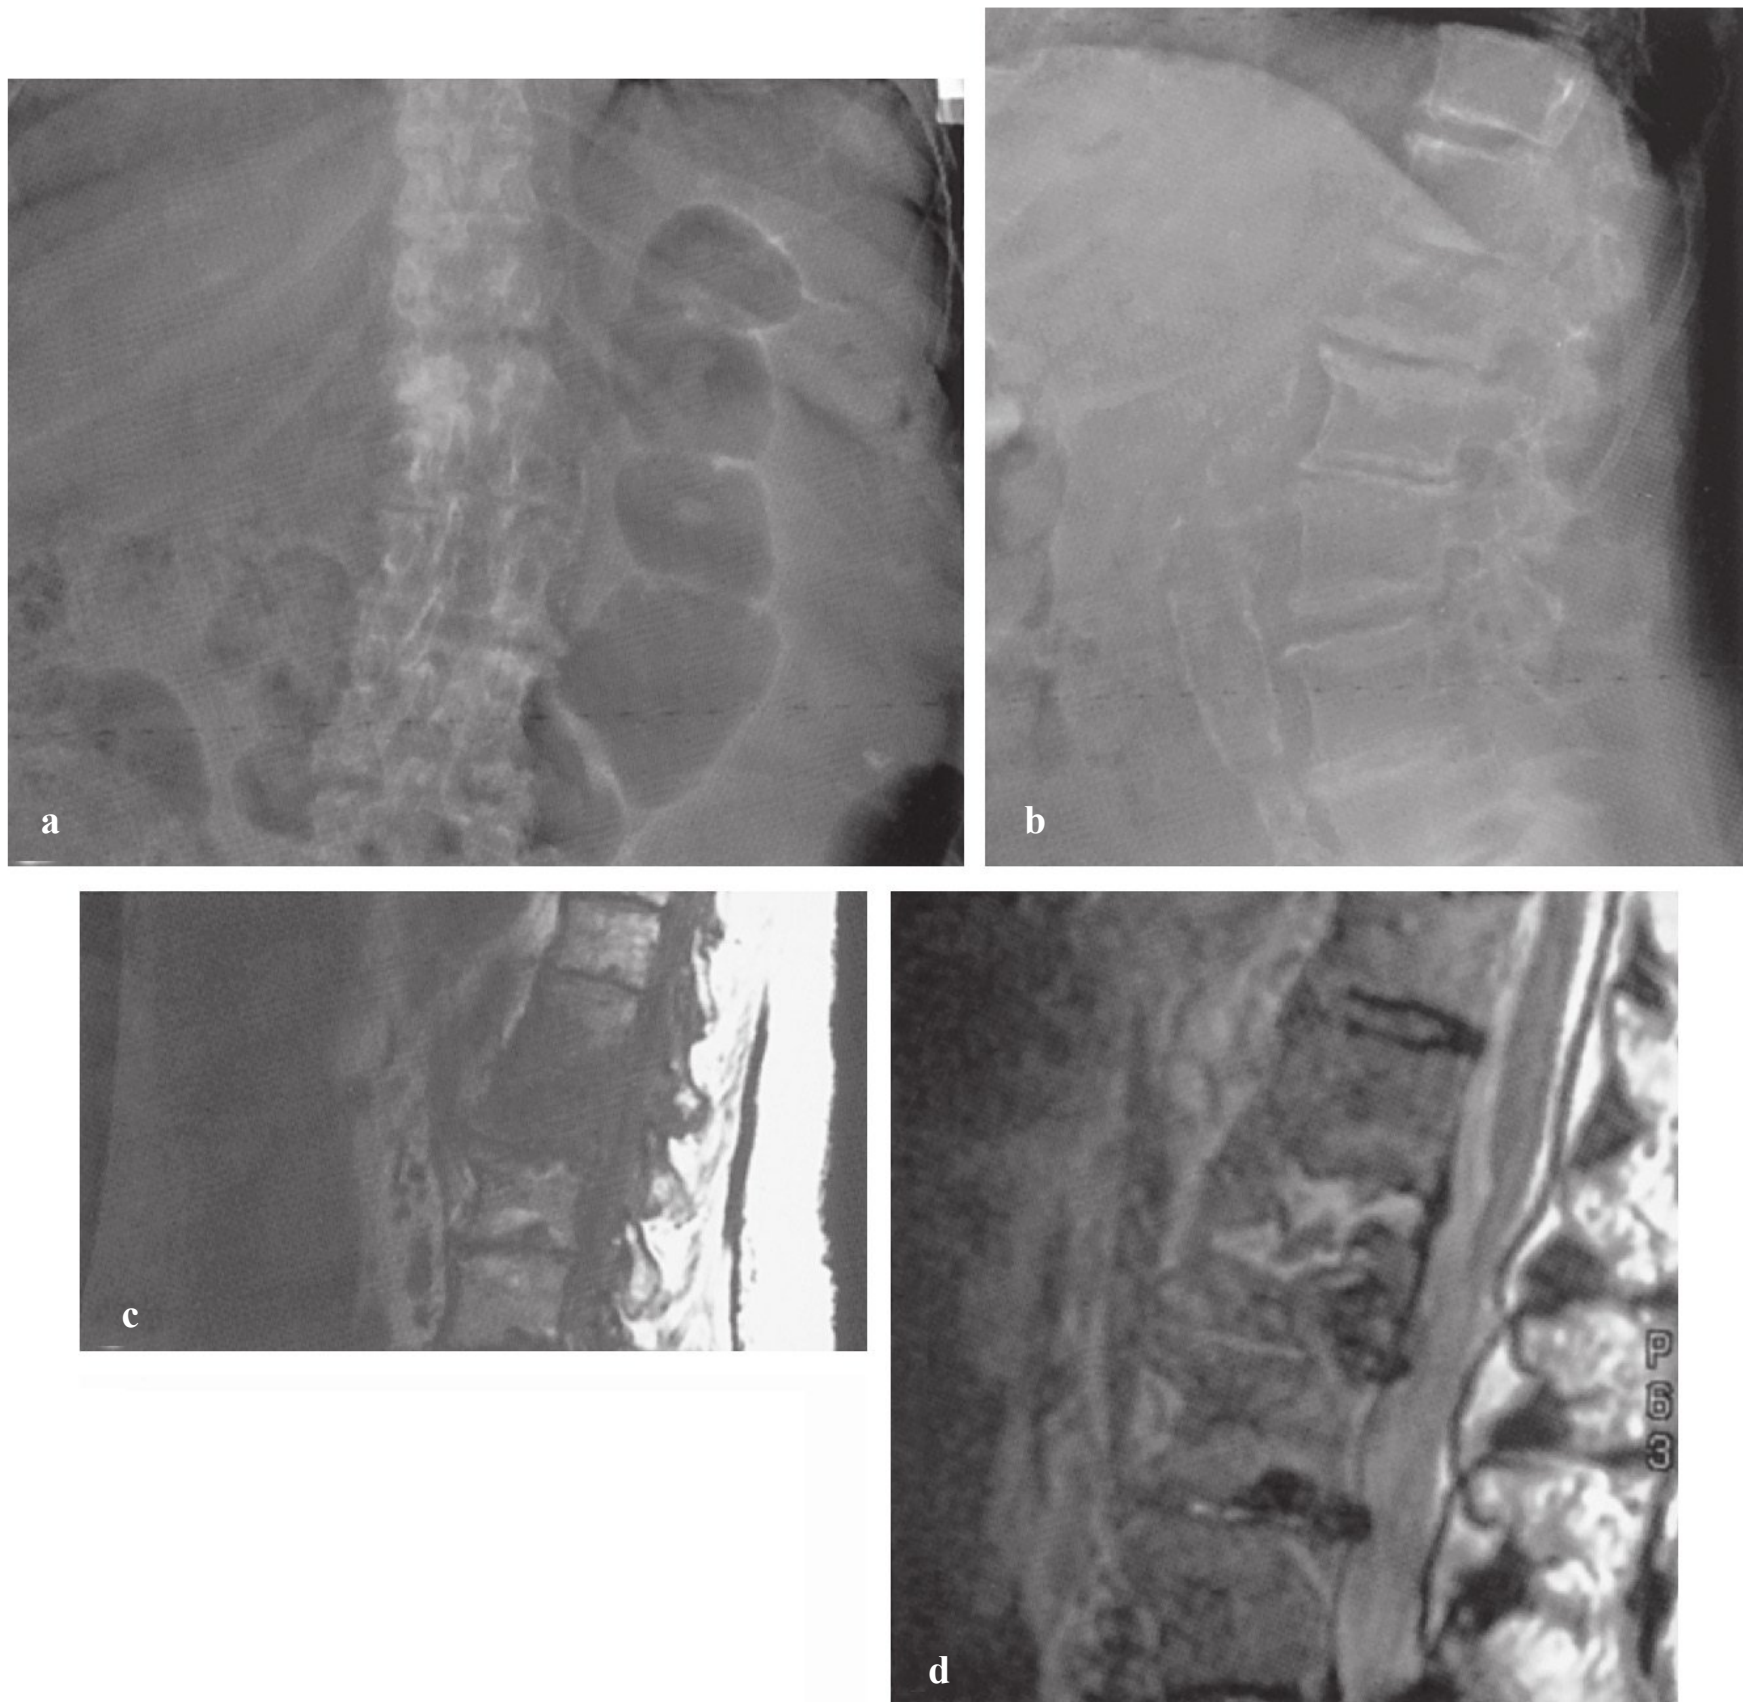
A 76-year-old woman with rheumatoid arthritis and a T12–L1 diskitis/L1 osteomyelitis. Results of three needle biopsies were negative. (a,b) Anteroposterior and lateral radiographs demonstrated a diskitis at T12–L1 with destruction of the L1 vertebral body. (c) T1-weighted sagittal magnetic resonance imaging (MRI) sequence shows decreased signal throughout and across the T12–L1 disk space. The end plates are blurred and indistinct. (d) T2-weighted sagittal MRI sequence shows high signal within the T12–L1 disk and the L1 vertebral body.
